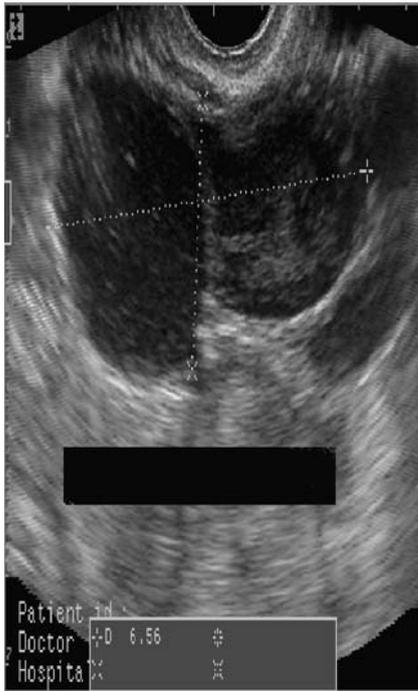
Ultrasonic picture of tubal tuberculosis
